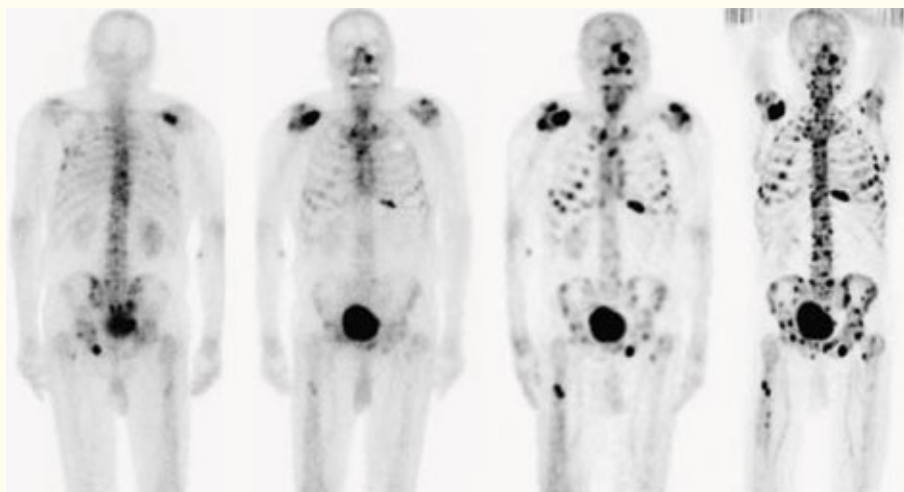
Bone metastases observed after injection of ^{99m}Tc -MDP on a planar scan (left) and a SPECT image (middle) compared to a ^{18}F -fluoride PET image (right). Reprinted by permission of SNMMI from Even-Sapir E et al., *J Nucl Med* 2006; 47: 287. Figure 1.
